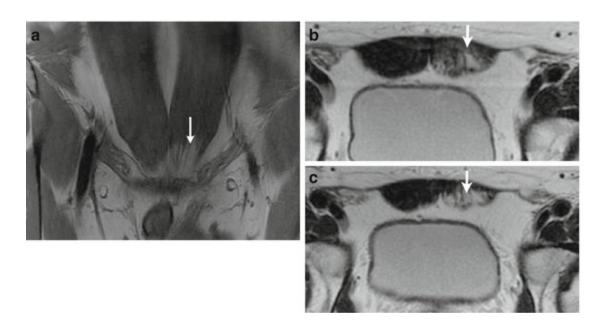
Coronal (a) and axial (b, c) T1-weighted MRI show left rectus abdominis amyotrophy (arrows) compared to the opposite one
